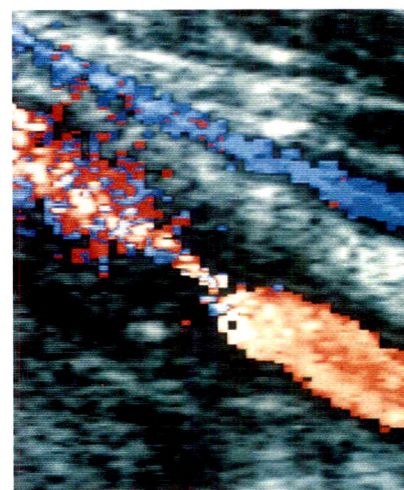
Longitudinal sonogram of common carotid artery with segmental high-grade stenosis in patient with atherosclerosis and prior neck irradiation. Sonography was performed during systole (note color bruit); indeterminate color assignment in perivascular tissues is caused by systolic vibration. Intravascular color flow aliasing is present. During diastole, there was a persistent flow jet, but no evidence of aliasing or perivascular tissue bruit.
